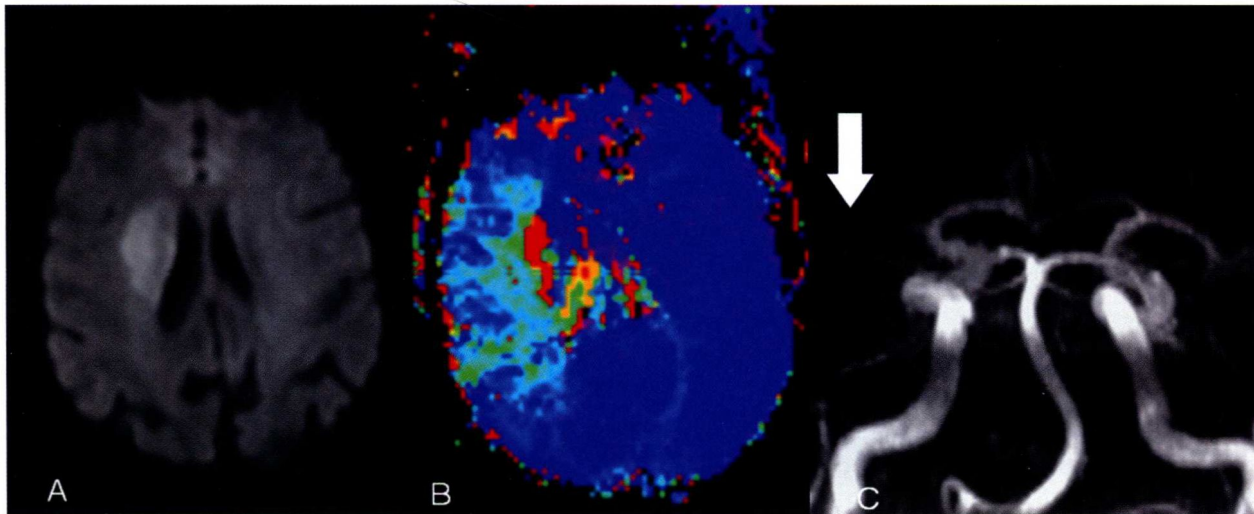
Utility of MRI as a trial tool for IA thrombolysis. (A) DWI, (B) PWI (MTT map), and (C) 3D time-of-flight (TOF) MRA are demonstrated in a patient with acute right MCA occlusion. Note a very small ischemic core on DWI, relatively large PWI defect, and occlusion of right M1 segment (arrow). This was successfully recanalized with IA thrombolysis, and neurologic deficits markedly improved.
